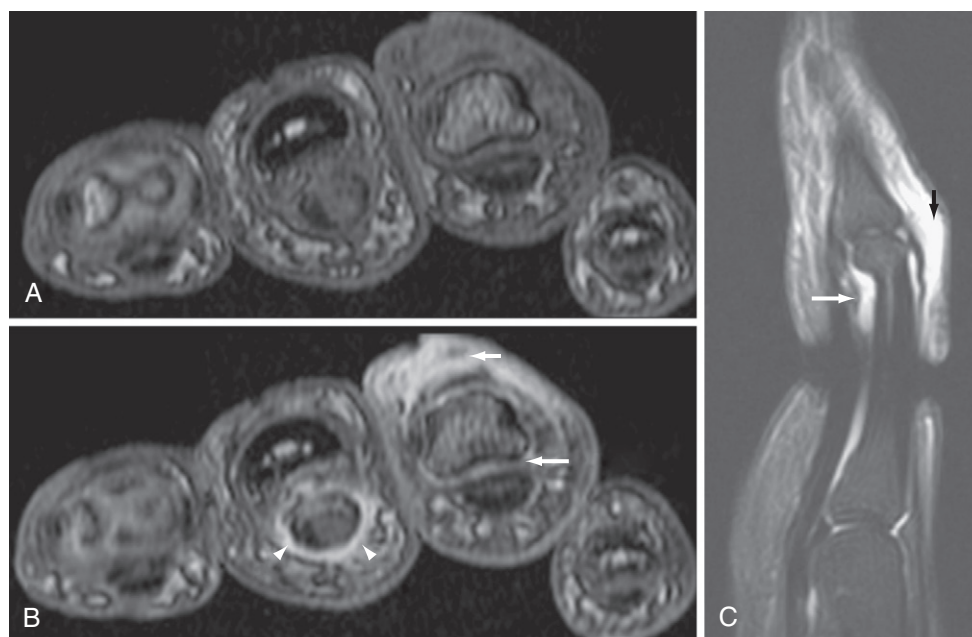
Psoriatic arthritis (magnetic resonance imaging [MRI]). Axial T1-weighted precontrast (A) and postcontrast (B) MRI of the second (left) through fifth (right) fingers at the level of the fourth proximal interphalangeal joint and sagittal short tau inversion recovery MRI (C) of the fourth finger show mild synovitis (long arrows in B and C) and considerable periarticular inflammation (short arrows in B and C) around the fourth distal interphalangeal joint and tenosynovitis (arrowheads in B). (Courtesy Rene Poggenborg, Glostrup, Denmark.)
